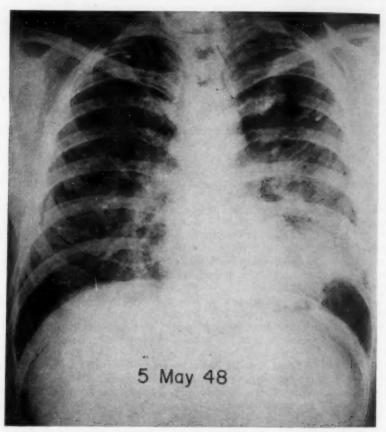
Case 4. Roentgenogram of the chest taken three months after onset of present illness. It reveals confluent infiltration in the left lower lobe with diffuse fine infiltration of the right lung.
